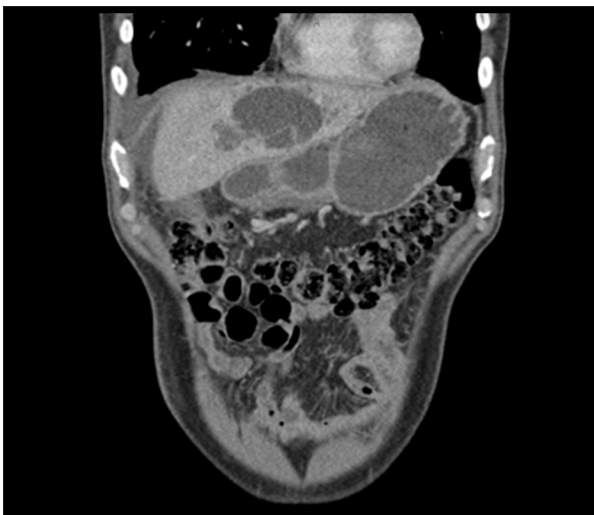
Computed tomography (coronal projection) depicting a 6-cm, ampulla-like, cystic-appearing hypodense left hepatic lobe lesion with bile duct and periampullary thickening resulting in mass effect and consequent duodenal stenosis.
